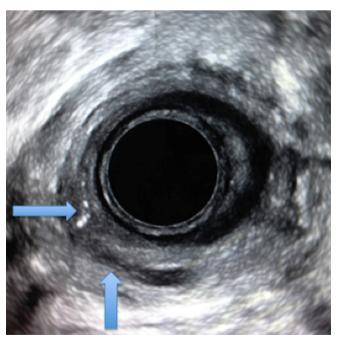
Endoscopic ultrasonography with a typical hypoechoic tubular image corresponding to the fistulous path. Hyperechoic foci correspond to air bubbles (arrows).
